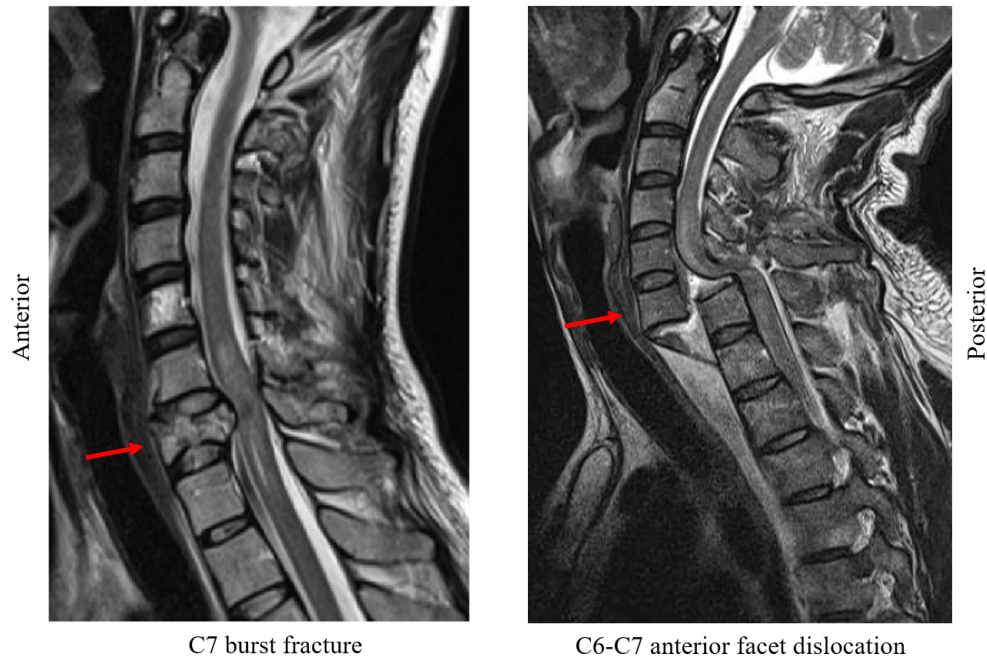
MRI stills of C7 burst fracture caused by a motor-bike fall (left) and severe anterior dislocation with fracture caused by automotive roll-over crash (right). Damage to the spinal cord (dark grey shade) can be seen in both accidents. Images obtained from *radiopedia.org*.
